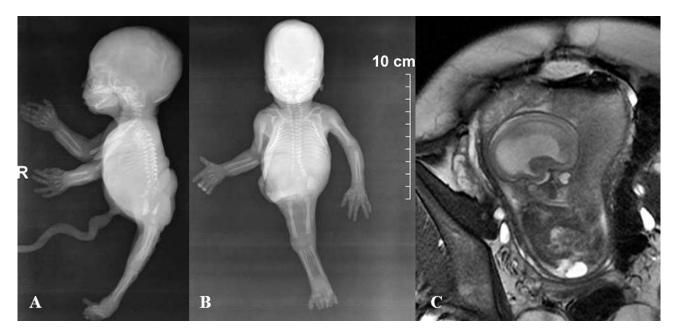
Sirenomelia. A and B. Radiography (face and profile). One lower limb with bones for two lower limbs and feet; C. Prenatal MRI visualizes the available hydrocephalus and defects of the lower spine and spinal cord.
